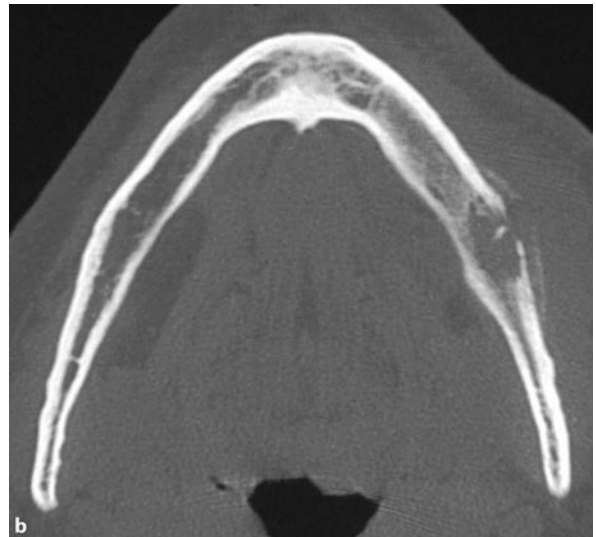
Localized subacute-phase acute osteomyelitis with calcified periosteal reaction in a 47-year-old patient with 2 weeks history of mild pain but substantial swelling of left cheek 3 weeks following extraction of 36. Axial high-resolution bone-window CT images (a,b) depict osteomyelitis with cancellous bone osteolysis, buccal cortical plate perforation and linear calcified periosteal reaction. Periosteal calcification adjacent to a central cortical
